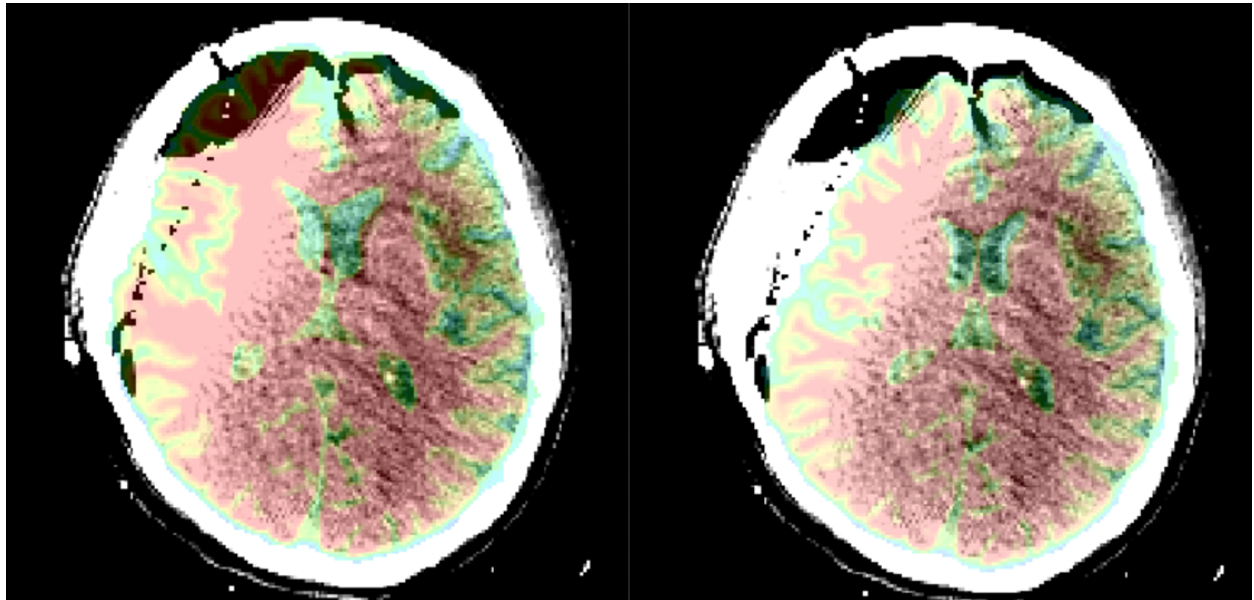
Coregistration of internal brain structures. CT is shown as grayscale background with colored MRI overlaid. Left is before transformation. Right is after transformation.
